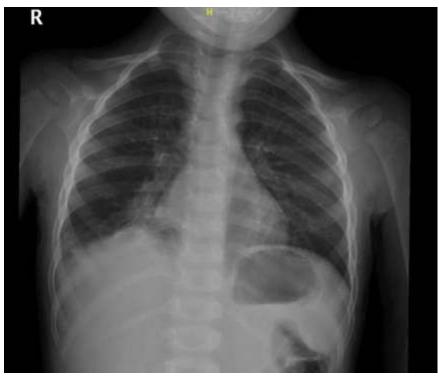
Chest X-ray on arrival demonstrating pulmonary hyperinflation leading to a plan for bronchoscopy to remove the suspected foreign body.
